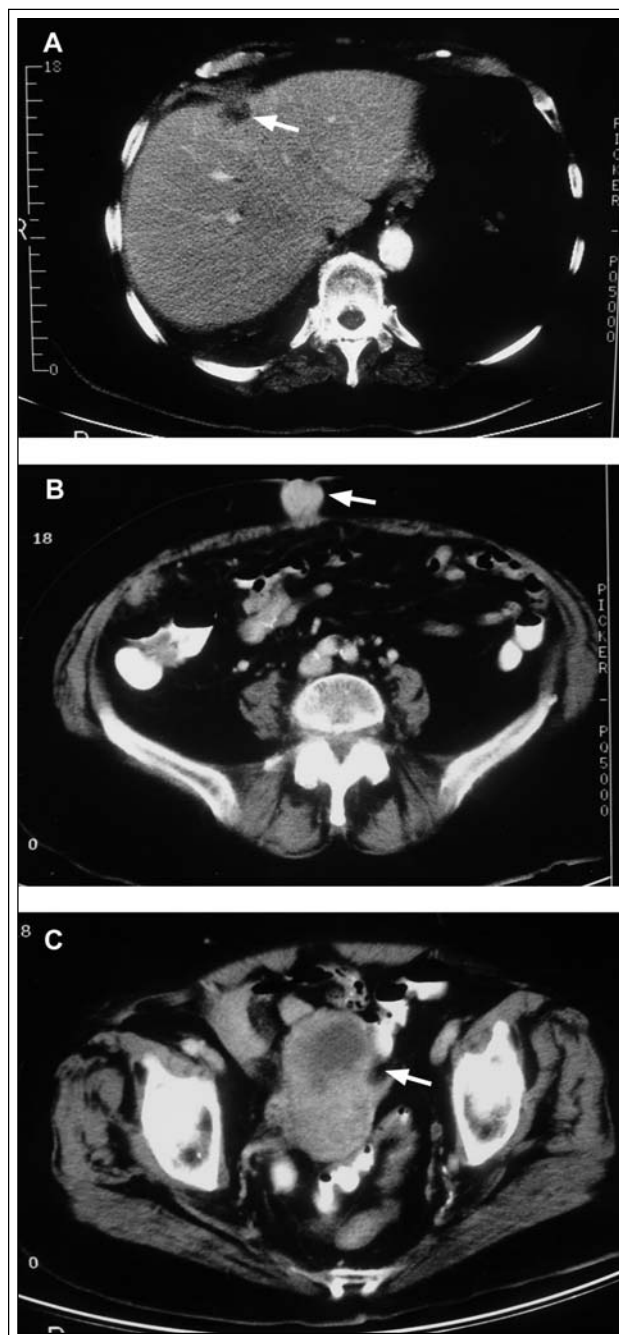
Computed tomography scan of the abdomen/pelvis revealing:
